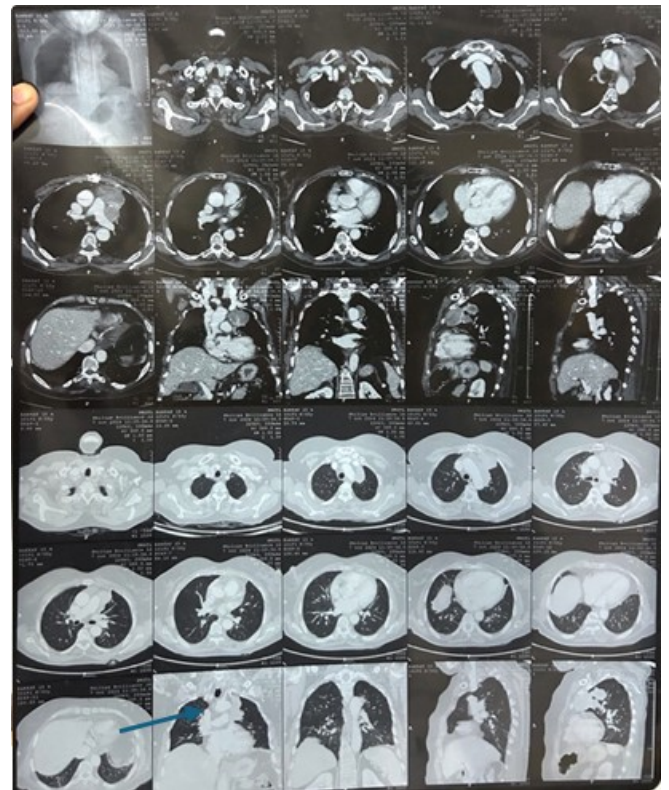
CECT Thorax showing Recurrence of thymoma (current CT Scan)
